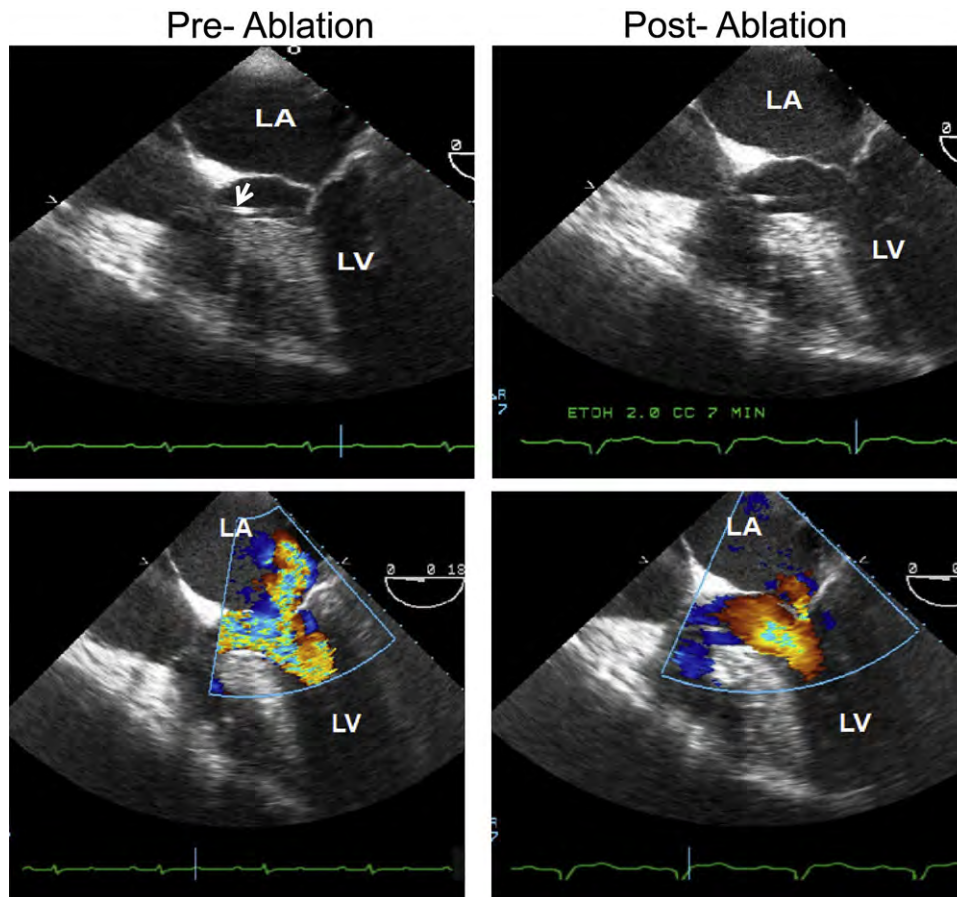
Transesophageal echocardiographic images from a patient who underwent alcohol septal ablation. Before ablation, 2D image shows narrowed LVOT with SAM (*top left*). (*Top right*) Two-dimensional images after ablation. Color Doppler before ablation shows high-velocity signals in mosaic color with eccentric mitral regurgitation directed posterolaterally (*bottom left*). After ablation, velocities are much lower across the LVOT, and mitral regurgitation appears trivial (*bottom right*). The arrow points to the catheter across the LVOT, which is used to measure LV pressure during the procedure. LA, Left atrium; LV, left ventricle.
